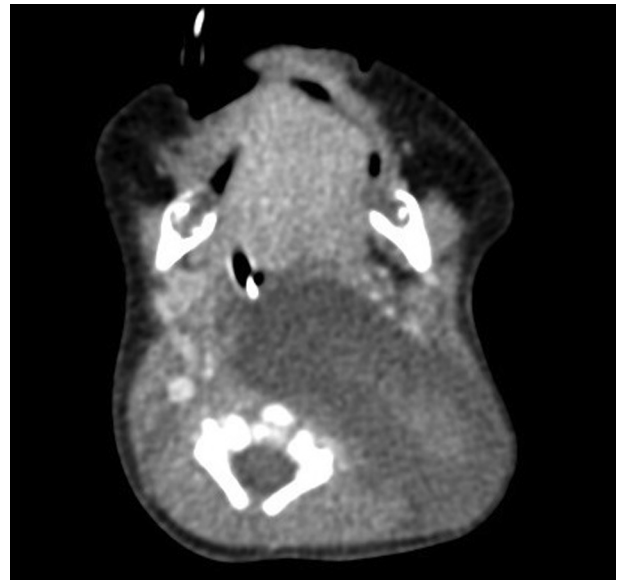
Computed tomography (CT) scan axial view demonstrating macrocystic malformation.
